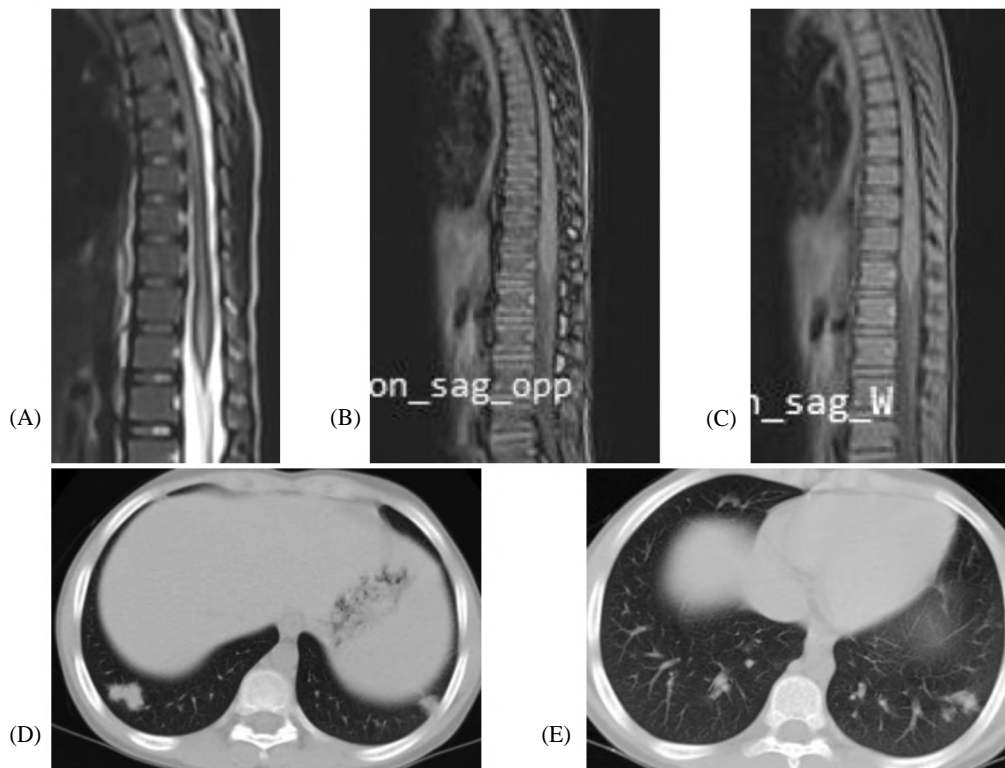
8 year old male boy with COVID 19, radiologically and laboratory proven, followed by bilateral lower limb weakness with sensory level, diagnosed with transverse myelitis. CT score of 8. (A) Sagittal T2WIs, (B,C) Sagittal post contrast T1 WIs with and without fat suppression, showing diffuse swelling of the lower part of the lumbar spinal cord and the conus medullaris with intramedullary abnormal high T2 signal and diffuse enhancement in the post contrast series. (D,E) Axial CT chest showing peripheral multifocal areas of airspace consolidation.
